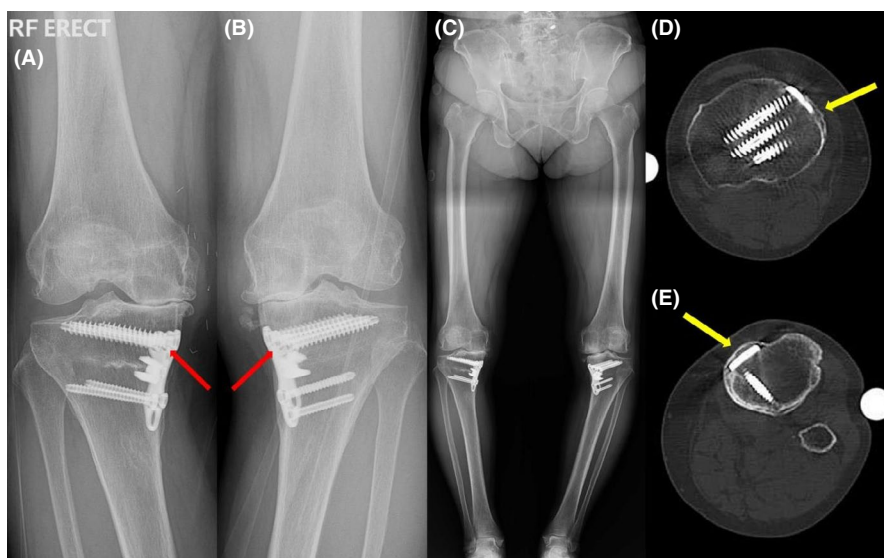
(A and B) Bilateral K-L grade IV osteoarthritic changes in a 69-year-old woman. Five years prior, she had undergone bilateral high tibial osteotomy to treat medial osteoarthritis. (C) A preoperative standing AP radiograph shows a right HKA angle of 12.6° and a left HKA angle of 16.5° . (D and E) A preoperative CT scan of the right (D) and left knees (E) shows metal plates covered with bone (yellow arrow)
